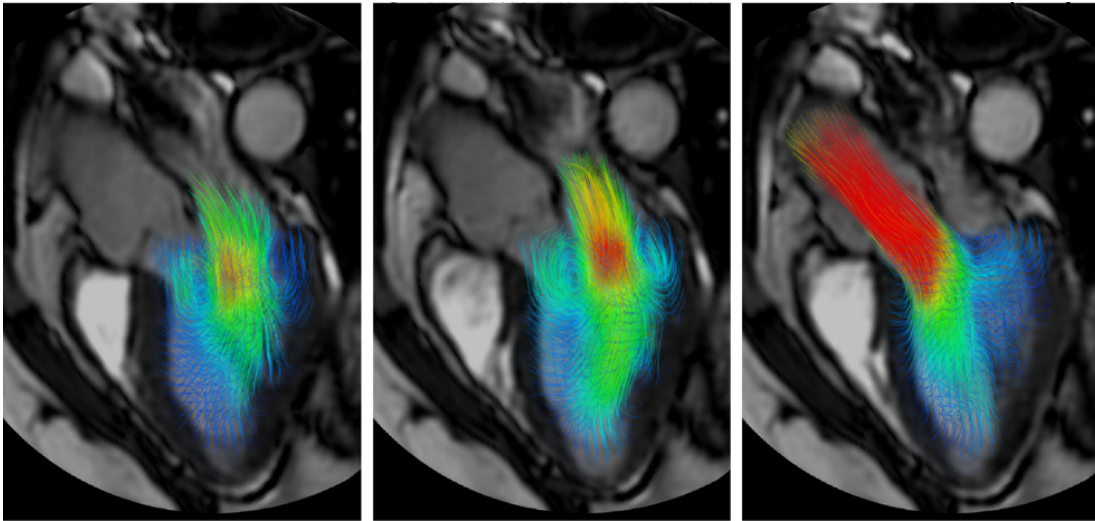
In vivo intracardiac 4D Flow MRI, extracted from [22].
